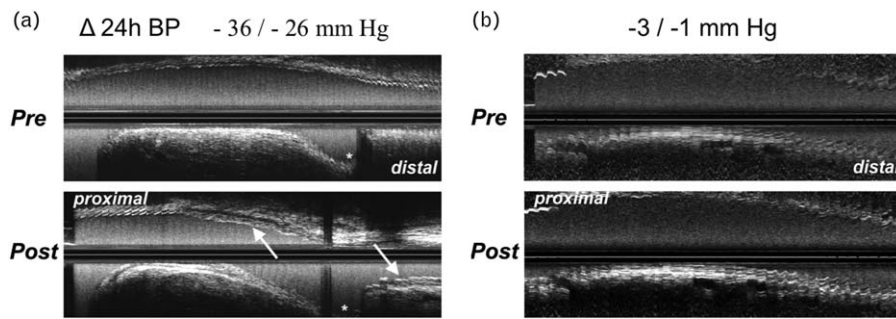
Two typical examples of renal artery changes (longitudinal reconstruction from intravascular ultrasound images) post renal denervation and their relationship with blood pressure changes. (a) Renal artery size decreased (lumen volume -29.5%) and wall volume increased ($+13.7\%$) (arrows) post renal denervation. After 1 month, 24-h blood pressure change was significant ($-36/-26$ mmHg). (b) Renal artery size remained virtually unchanged following renal denervation (lumen volume -2.8%), as did renal artery wall volume ($+3.7\%$). After 1 month, 24-h blood pressure was also virtually unchanged ($-3/-1$ mmHg).
